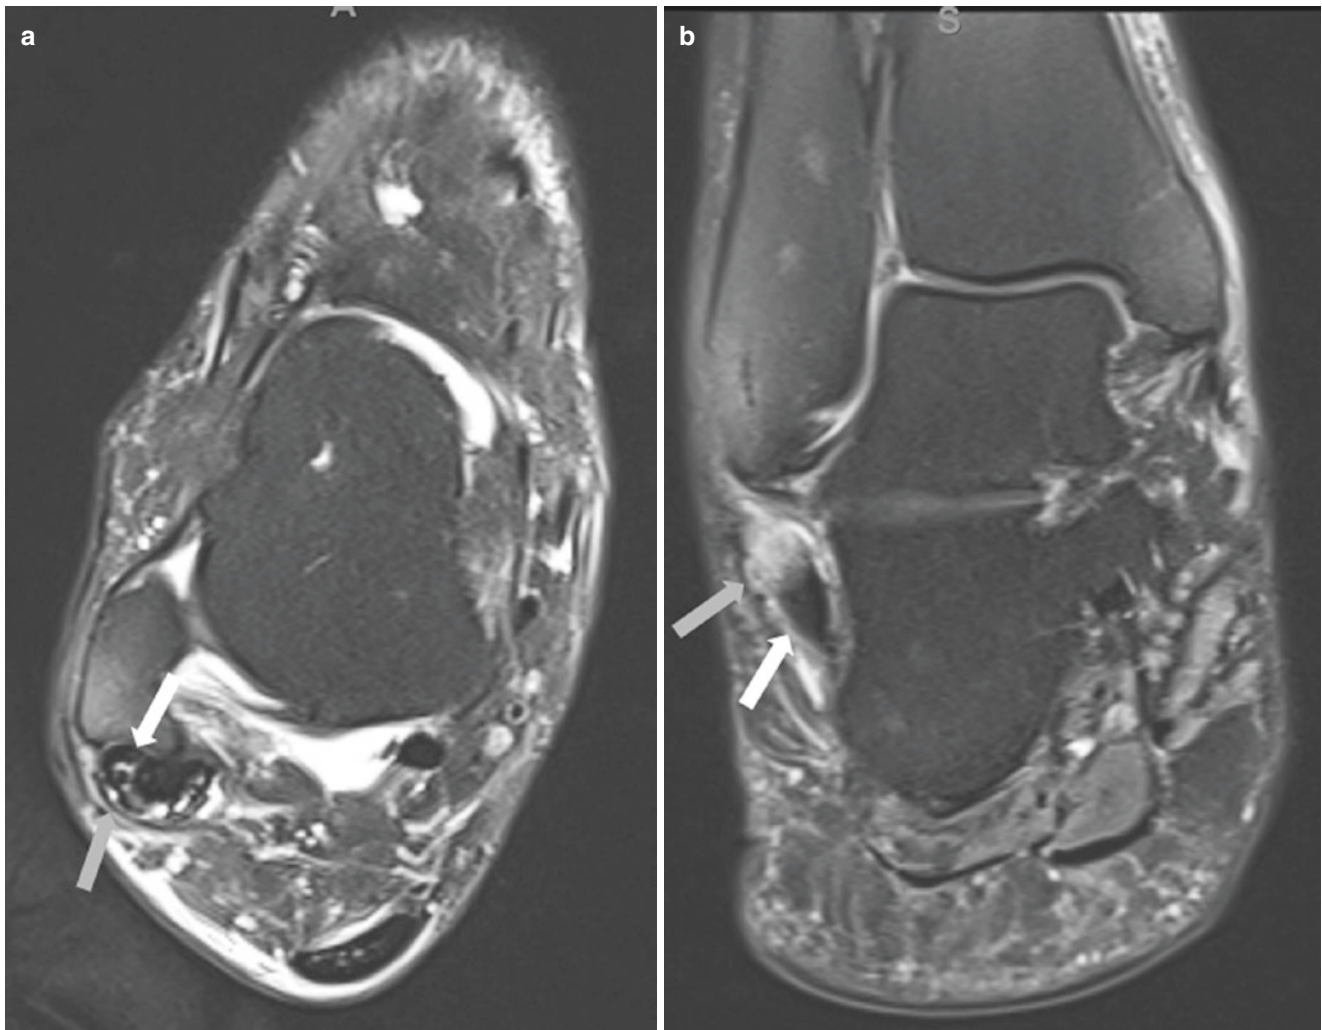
Peroneal stenosing tenosynovitis. Axial (a) and coronal (b) fat-suppressed T2-weighted MR images of the right ankle demonstrate peroneus brevis and longus tendinosis with partial-thickness tearing (*white arrows*), surrounding tendon sheath thickening and scarring (*gray arrows*)
